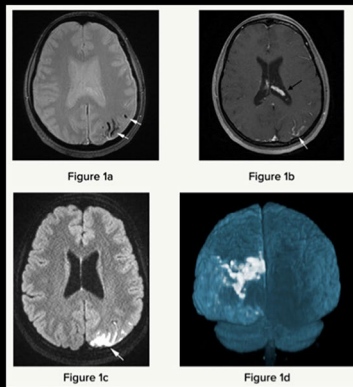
Axial Gradient - Echo MRI shows cortical calcifications in the left occipital cortex as low signal intensity (arrows) (a). Axial contrast-enhanced T1 weighted image shows enlarged, enhancing left choroid plexus (black arrow). Axial contrast-enhanced T1 weighted image demonstrates pial enhancement due to pial angiomas (white arrow) (b). Axial post-contrast fluid-attenuated inversion recovery image shows pericortical gadolinium enhancement (arrow) (c). Back view of the three-dimensional volume rendering of post-contrast FLAIR
